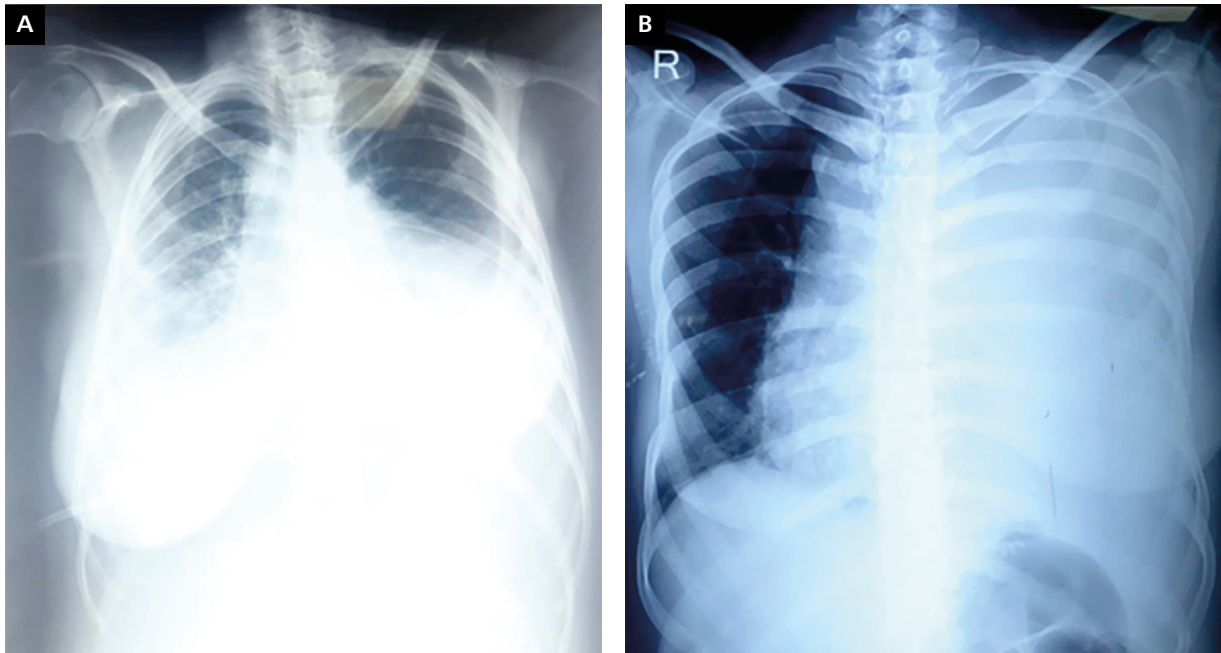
Chest radiography with malignant pleural effusion [9]
